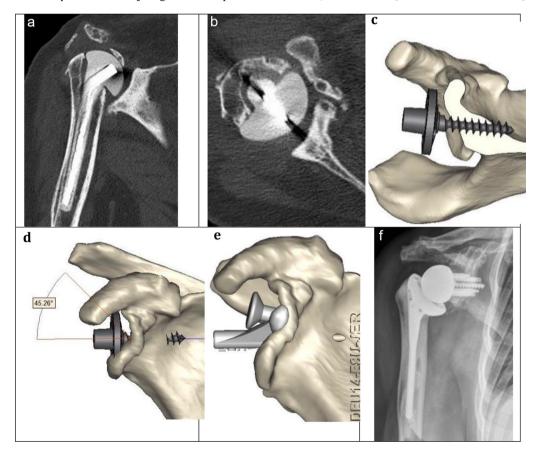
a-f. RSP Matchpoint Reverse Shoulder Arthroplasty (DJO Global, Austin, TX, USA) for massive glenoid bone loss. (a) Pre-opertaive x-ray demonstrating cement spacer with medialisation. (b) Pre-operative CT scan revealing significant glenoid bone loss and posterior retroversion. (c & d) Preoperative planning with RSP baseplate positioned for bicortical fixation and graft compression (Materialise NV, Leuven, Belgium) (e) Matchpoint jig position for central drill hole preparation. (f) Post-operative x-ray following glenoid allograft grafting and RSP insertion.
